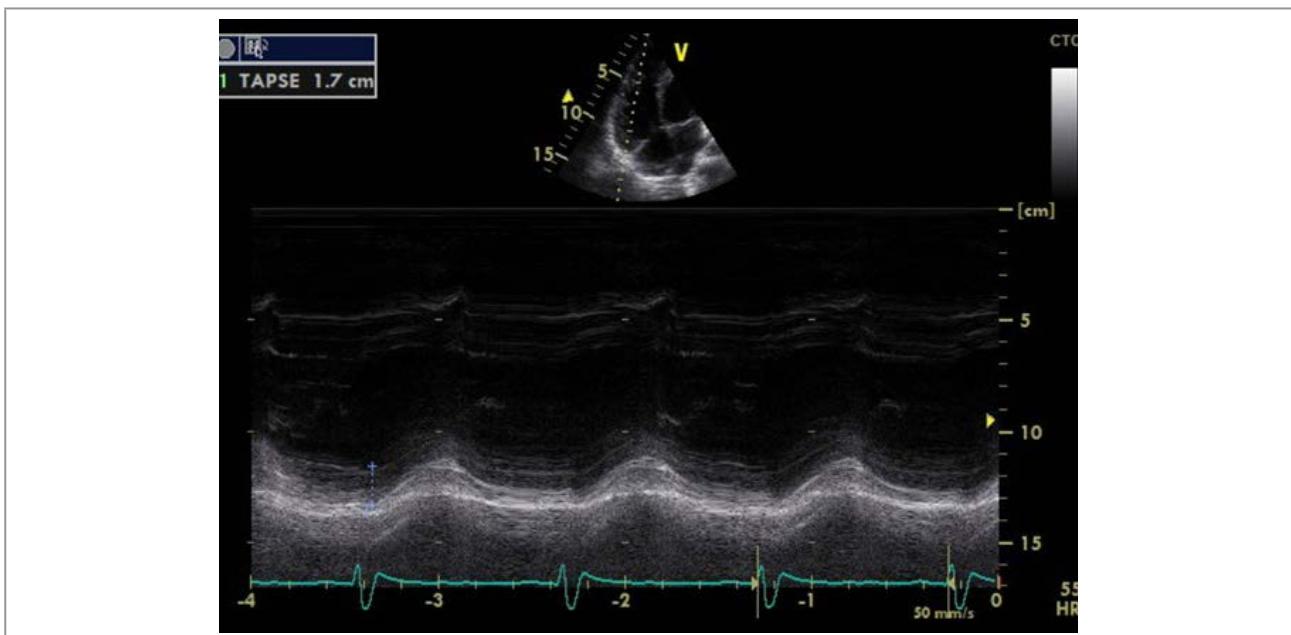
Echocardiography showing tricuspid annular plane systolic excursion (TAPSE) of 17 mm.
